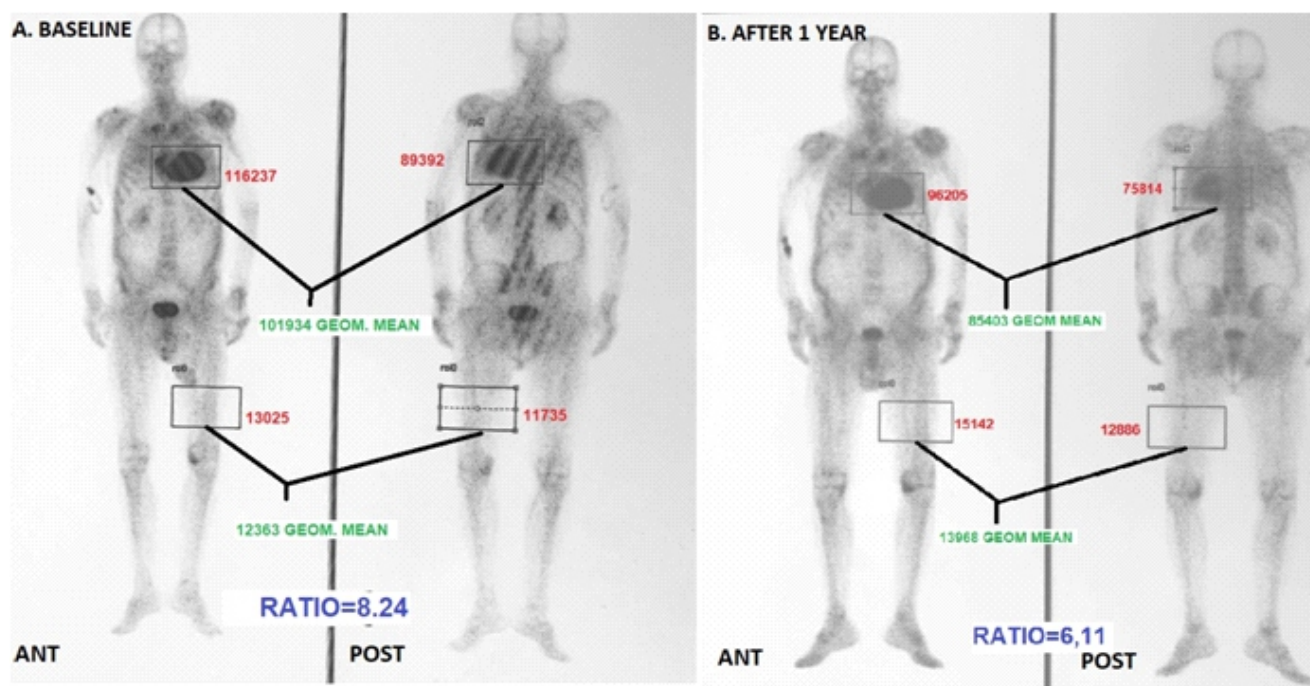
Myocardial scintigraphy with ^{99m}Tc -DPD in a patient with wild type transthyretin amyloidosis at baseline and after one year of Tafamidis therapy. The geometric mean was computed for both cardiac and thigh ROI and the HtT ratio was assessed by dividing the corresponding geometric mean counts.
